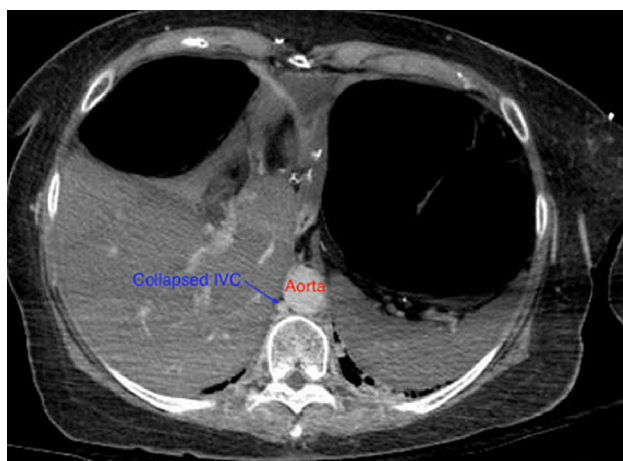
Figure C CT chest/abdomen/pelvis axial view demonstrated collapsed abdominal inferior vena cava.
